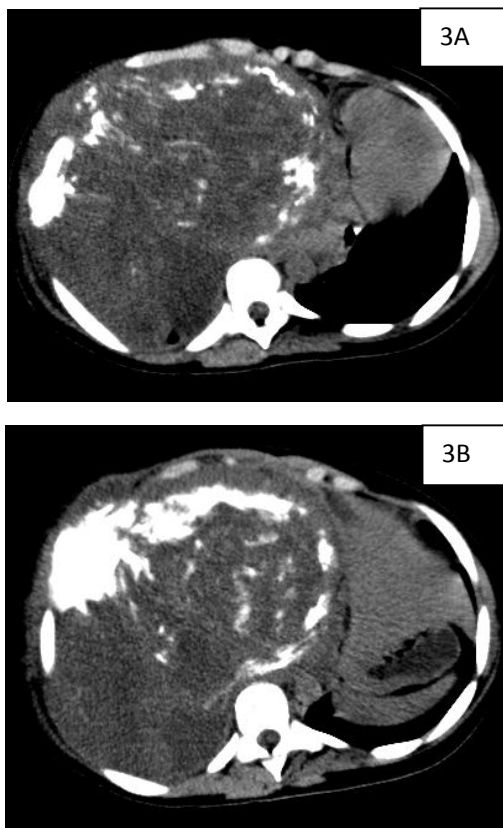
Non contrast Axial CT images showing the extensive heterogeneous mass with heavy coarse calcification and extension across the midline to the left
